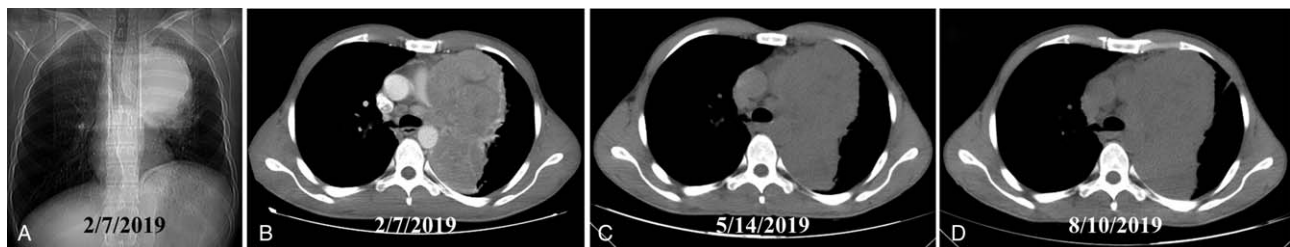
The bulky pulmonary lesion (indicated by arrow) before and after treatment in case 2. A. The X-ray showed a giant mass located in left upper thorax. B. Computed tomography revealed the pulmonary tumor invading adjacent pulmonary veins. C. The tumor showed stable disease after 3 months of treatment. D. The lesion remained stable 6 months later. SD=stable disease.
